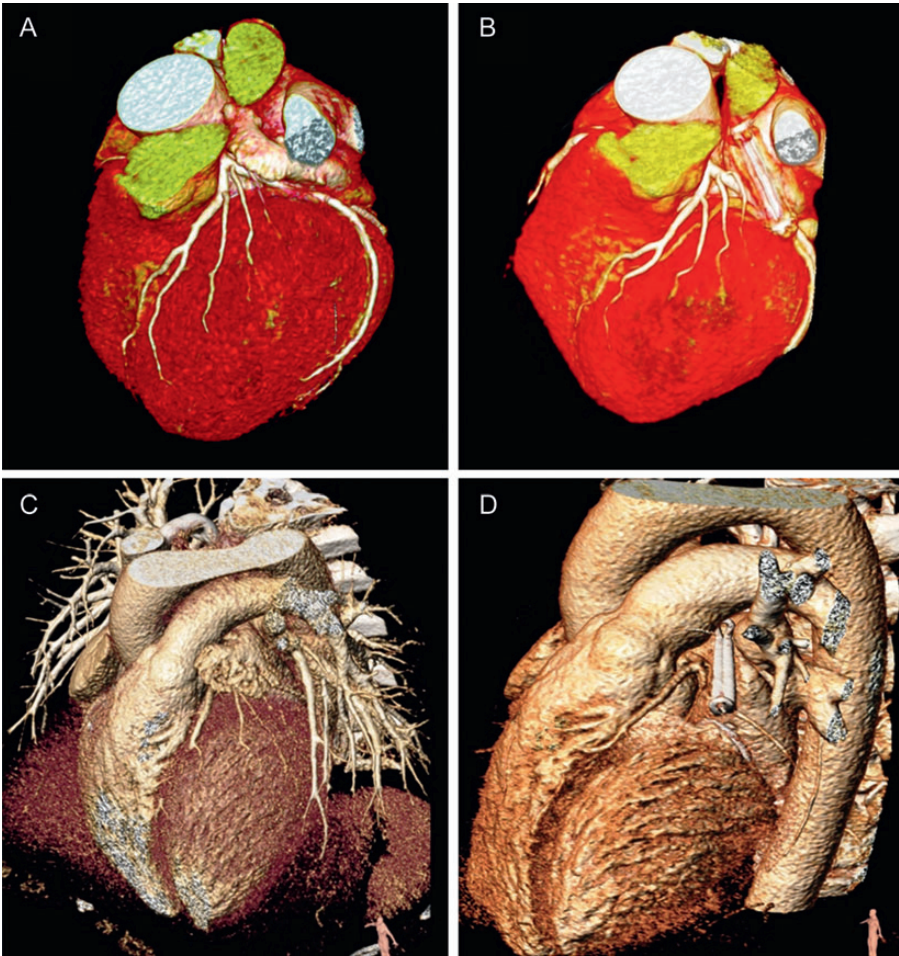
Computed tomography (CT) before and at 3-year follow-up after clip implantation. Exemplary CT before clip placement (A and C) and after clip implantation depicting the clip in stable position and fully excluding the left atrial appendage at a 3-year follow-up (B and D).
